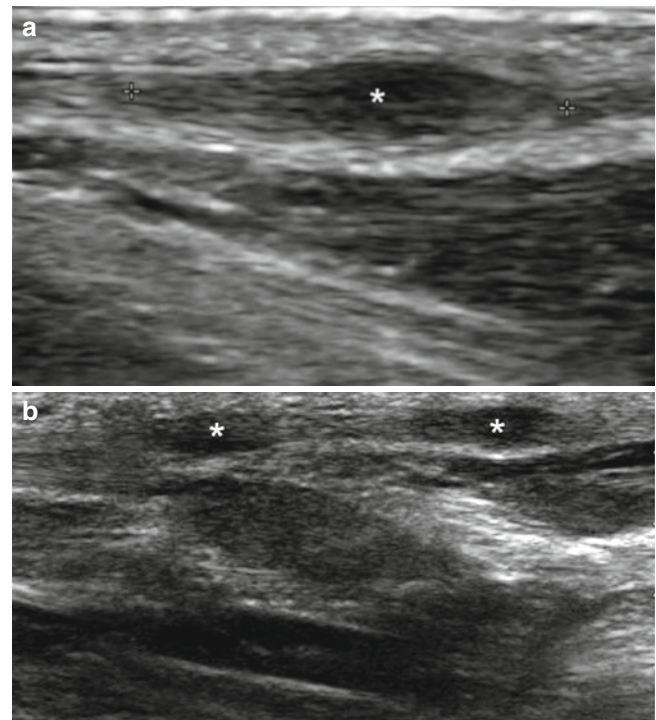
(a, b) Plantar fibromatosis-Ledderhose's disease. (a, b) Grey scale ultrasound images (b zoomed longitudinal view; c extended longitudinal view) show fusiform shaped hypoechoic nodules (*, between markers) within the medial aspect of the plantar fascia in the right foot
